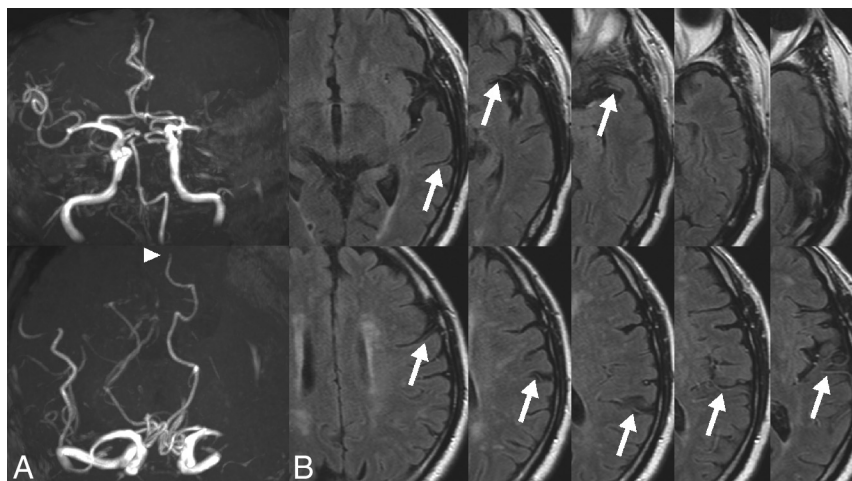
PCA laterality sign and hyperintense vessels on MR images. A, MRA shows an occlusion of the M1 portion of the left MCA and signal extent of the ipsilateral PCA (arrowhead). B, FLAIR MR imaging shows hyperintense vessels (arrows) in 8 of 10 axial sections.
